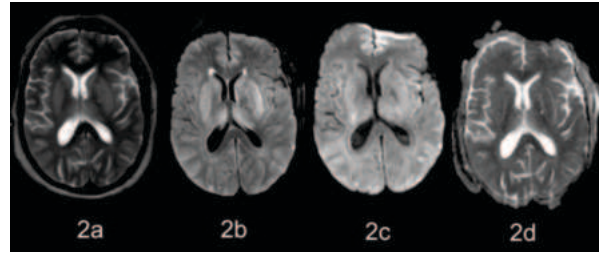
(a-d) Post OP MRI brain: 2.a) & b) Axial section showing bilateral symmetrical T2 and FLAIR hyperintense areas with lentiform rim sign seen involving the basal ganglia; 2.c) & d) Axial section showing no diffusion restriction on DWI and ADC drop in corresponding areas.
